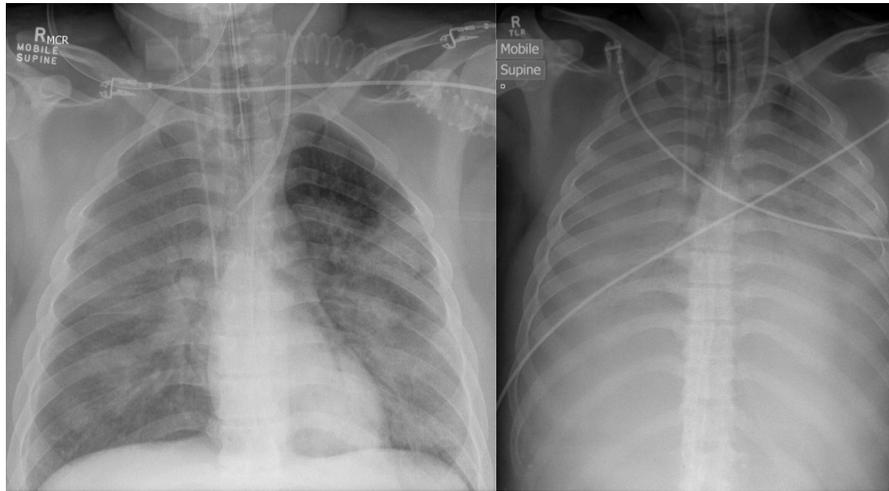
Chest X-ray showing lungs before VV-ECMO (L) and 24-h after initiating VV-ECMO (R).
